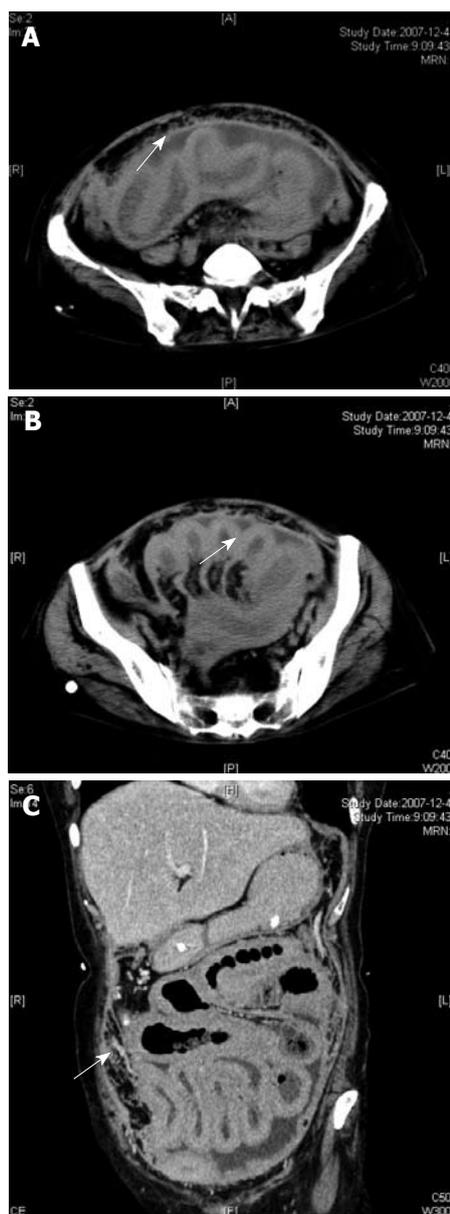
CT showing pronounced contrast enhancement of peritoneum and thickened intestinal wall. A: Most nodules coalesced to form large omental plaques (omental cakes); B: A moderate amount of ascites located between intestinal canals; C: No actual large abdominal masses.
